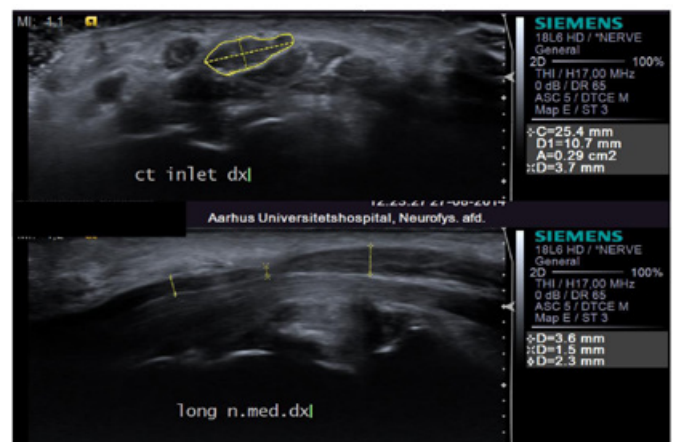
Figure shows a transverse ultrasound image of a swollen median nerve at the carpal tunnel inlet and a notch sign on the longitudinal scan, confirming the diagnosis of entrapment.
